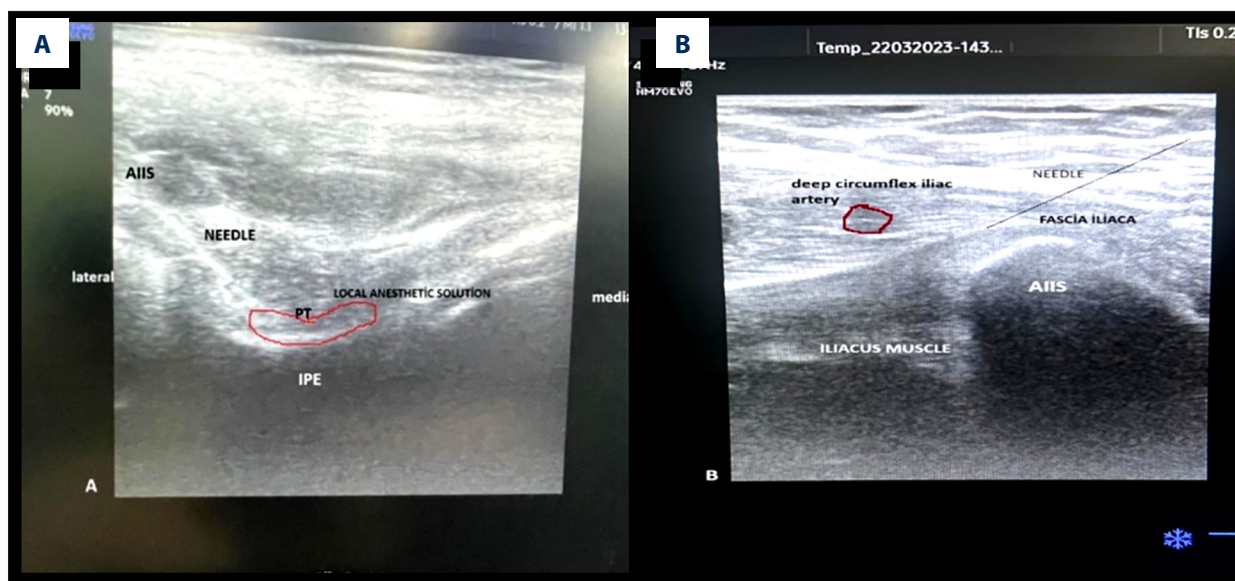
Ultrasound-guided block techniques used in the study. (A) Ultrasound-guided pericapsular nerve group (PENG) block. (B) Ultrasound-guided suprainguinal fascia iliaca (SIFI) block. Abbreviations: AIIS, anterior inferior iliac spine; IPE, iliopubic eminence; PT, psaos tendon.
